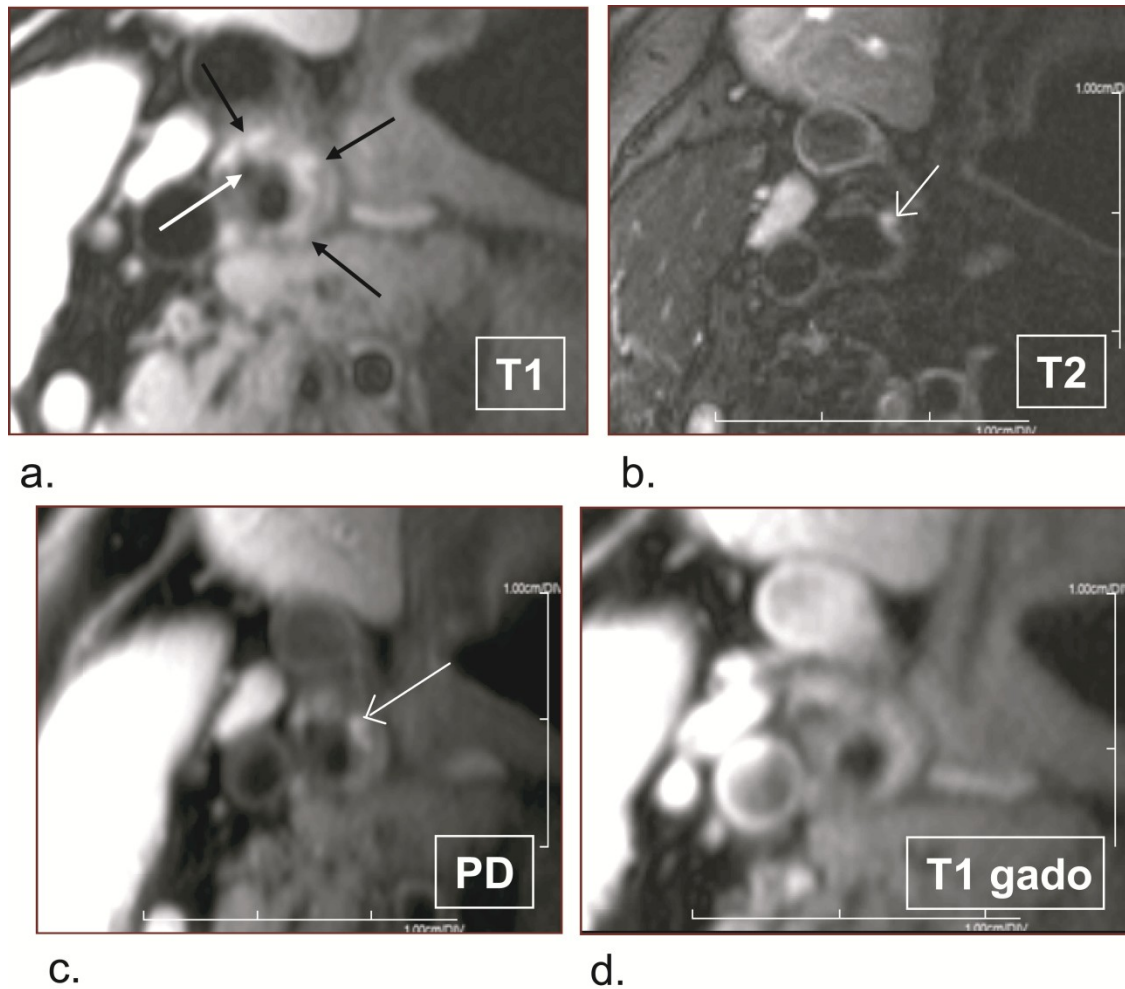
High-resolution cross-sectional MRI of the right carotid bifurcation of an asymptomatic patient. (a) On T1-weighted acquisition of right internal carotid artery stenosis, the plaque appears to be heterogeneous. The external carotid artery lumen is observed (white arrow), and both vessel walls consist of heterogeneous signals reflecting fibro-calcific tissue. (b) and (c) T2-weighted and Proton Density images show a hyperintense area not clearly apparent on T1 pre and post contrast images. This hyperintense area likely represents loose matrix fibrous tissue. (d) There is no significant plaque enhancement after gadolinium injection, suggesting that there is no neovascularisation or inflammation.
